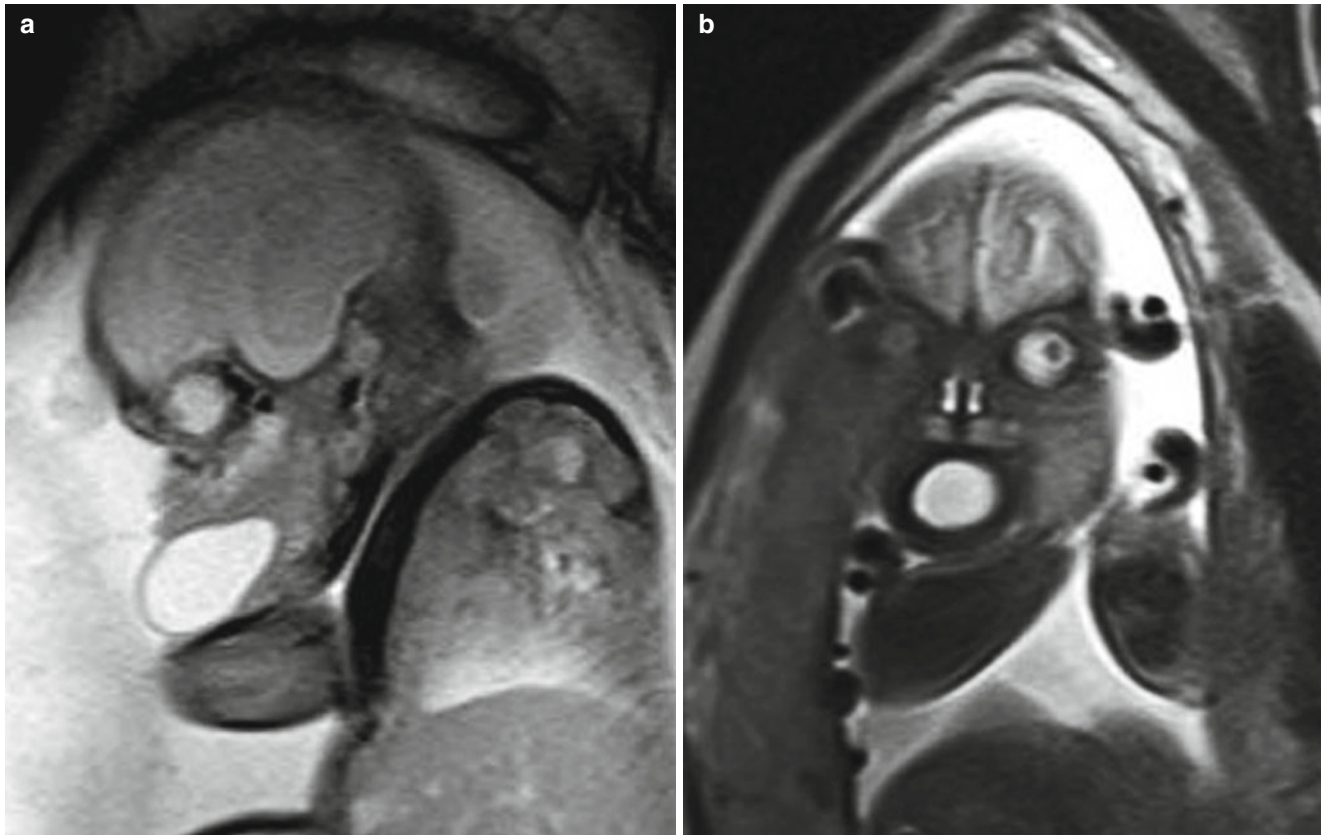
Enteric duplication cyst in a fetus. (a) Sagittal T2-weighted MR image shows an oval-shaped cystic mass occupying the anterior two-thirds of the fetal mouth. (b) Axial and T2-weighted image shows the cystic mass in the fetal mouth
